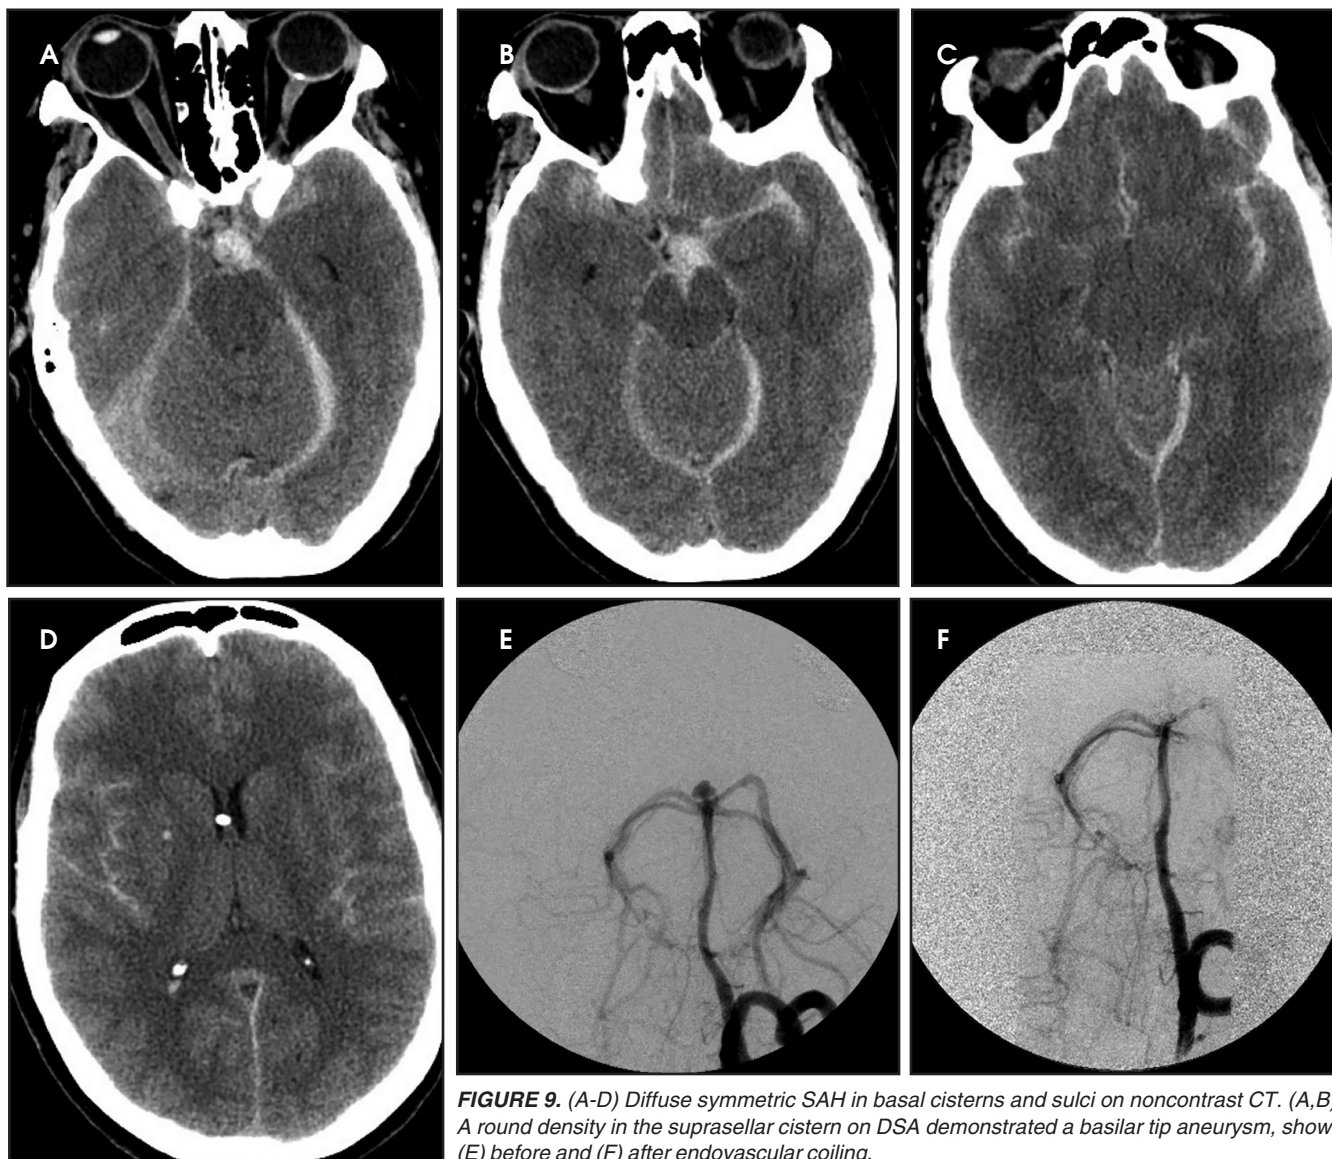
(A-D) Diffuse symmetric SAH in basal cisterns and sulci on noncontrast CT. (A,B). A round density in the suprasellar cistern on DSA demonstrated a basilar tip aneurysm, shown (E) before and (F) after endovascular coiling.
